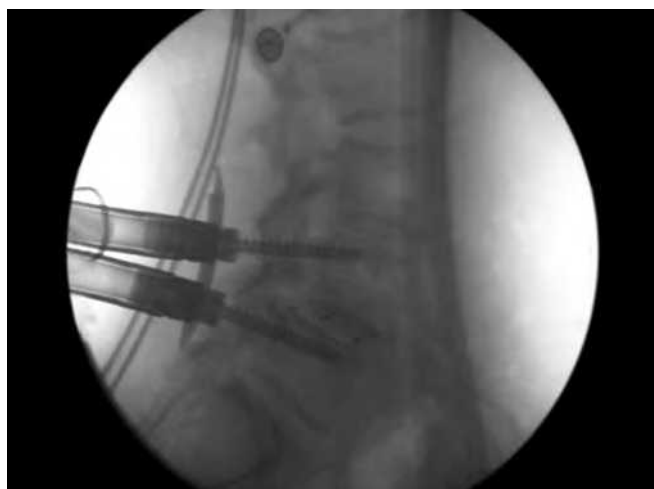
Intraoperative X-ray shows placement of cage and percutaneous pedicle screws.
